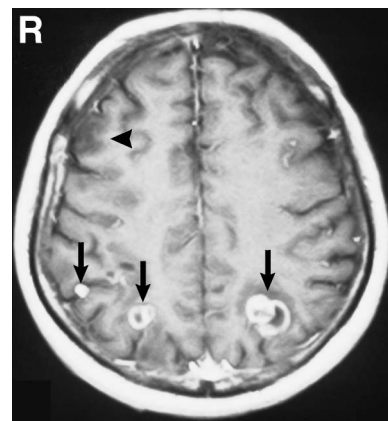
Axial T₁-weighted magnetic resonance image after gadolinium infusion performed 1 month following tumor removal showing total resection of the right frontal tumor (arrowhead) and significant growth of the untreated metastatic foci (arrows).
